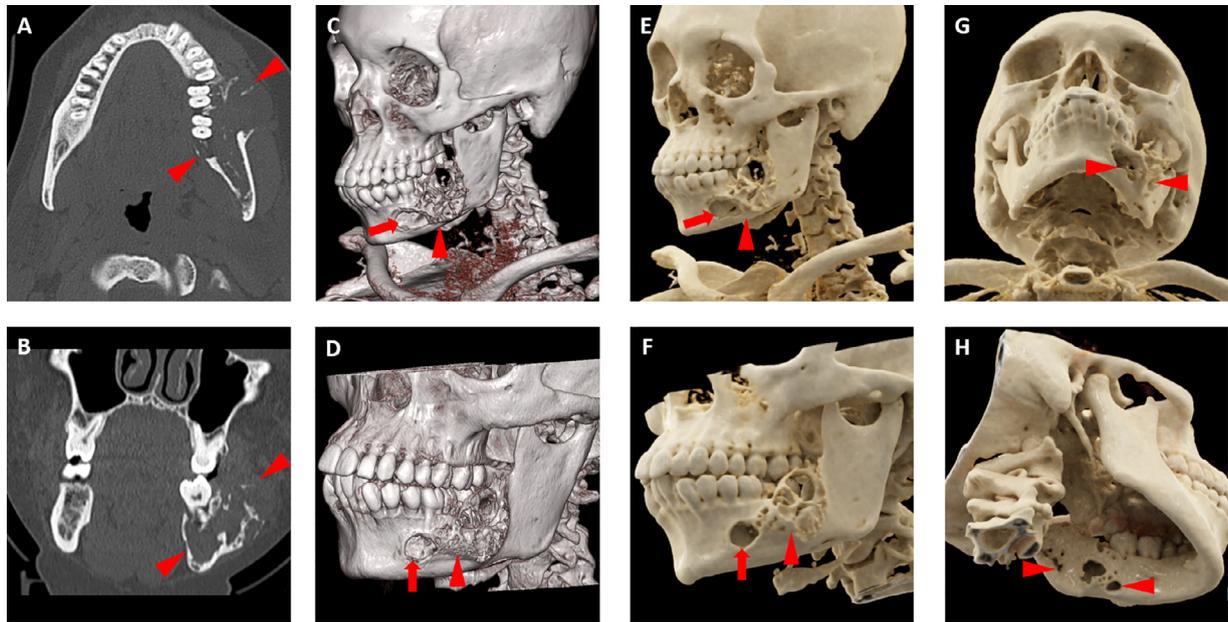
(A) Axial non-contrast maxillofacial computed tomography (CT) image through the mandible demonstrates a radiolucent expansile lesion centered in the left body of the mandible and extending to the left angle (*red arrowheads*) with both buccal and lingual surface soft tissue components and with medial displacement of the adjacent left mandibular molars. This lesion was found to be an odontogenic myxofibroma following resection. (B) Coronal, noncontrast, maxillofacial CT image also demonstrates the lytic nature of the lesion with a significant associated soft tissue component (*red arrowheads*). (C–D) Volume rendered visualizations from a predominantly left anterior oblique orientation effectively demonstrate the odontogenic myxofibroma (*red arrowheads*) and allow for a superior visual overview of the lesion relative to the 2-dimensional (2D) images in (A) and (B). The replacement of much of the left mandibular body by the lesion is readily apparent. (E–F) Cinematic-rendered (CR) visualizations of the odontogenic myxofibroma from similar left anterior oblique perspectives as in (C) and (D). The photorealism of the cinematic rendered images can be noted; this is particularly apparent in some of the deeper mandibular radiolucencies, which are much more realistically shadowed in (E) and (F) than in (C) and (D) (*red arrows*). (G–H) Additional CR images from a caudal perspective at the skull base (G) and from a caudal right posterior oblique projection (H) provide additional views of the odontogenic myxofibroma (*red arrowheads*).
